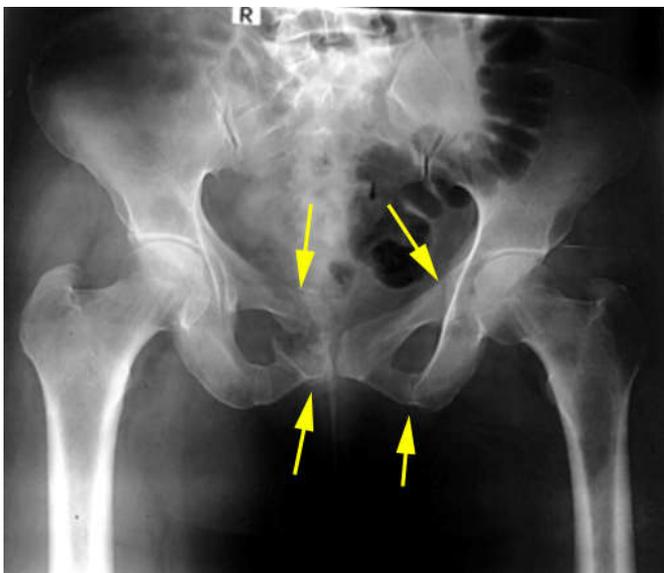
Pelvic radiograph of the patient. Arrows indicate bilateral superior and inferior pubic rami fractures
